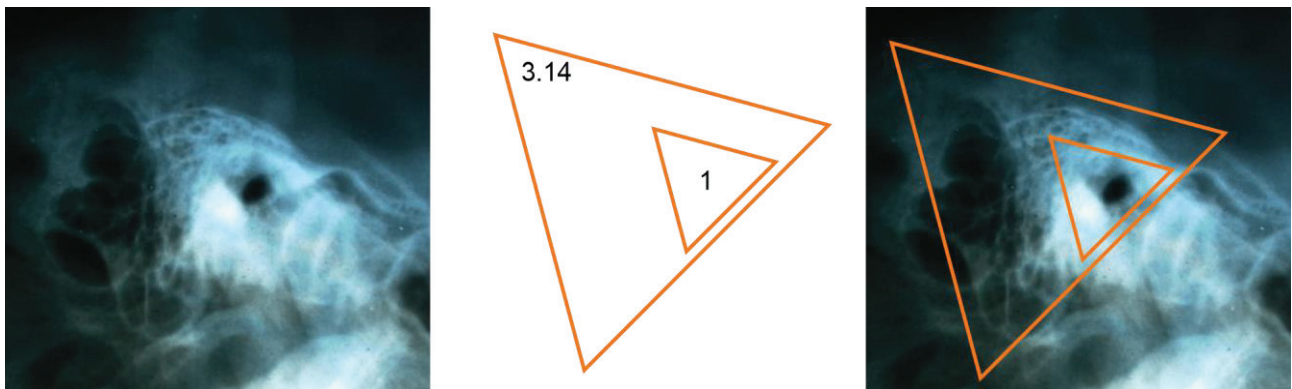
URCOTEBS_b. The measuring gauge and the projection area of the Anatomic Macroscopic Radiopaque Peripheral Support of the D-Organ superimposed on the radiographic image of the TB. In the case of a URCOTEBS_b, the projection area has a mean value 3.14 times larger than the gauge area (see Table 4, column 7).
